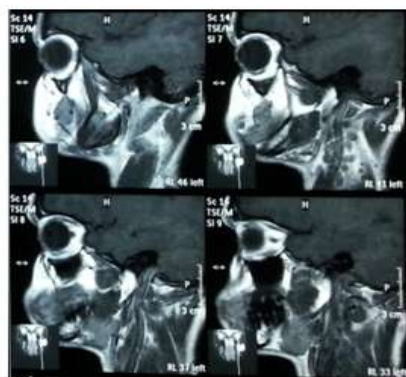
MRI contrast- Sagittal View
